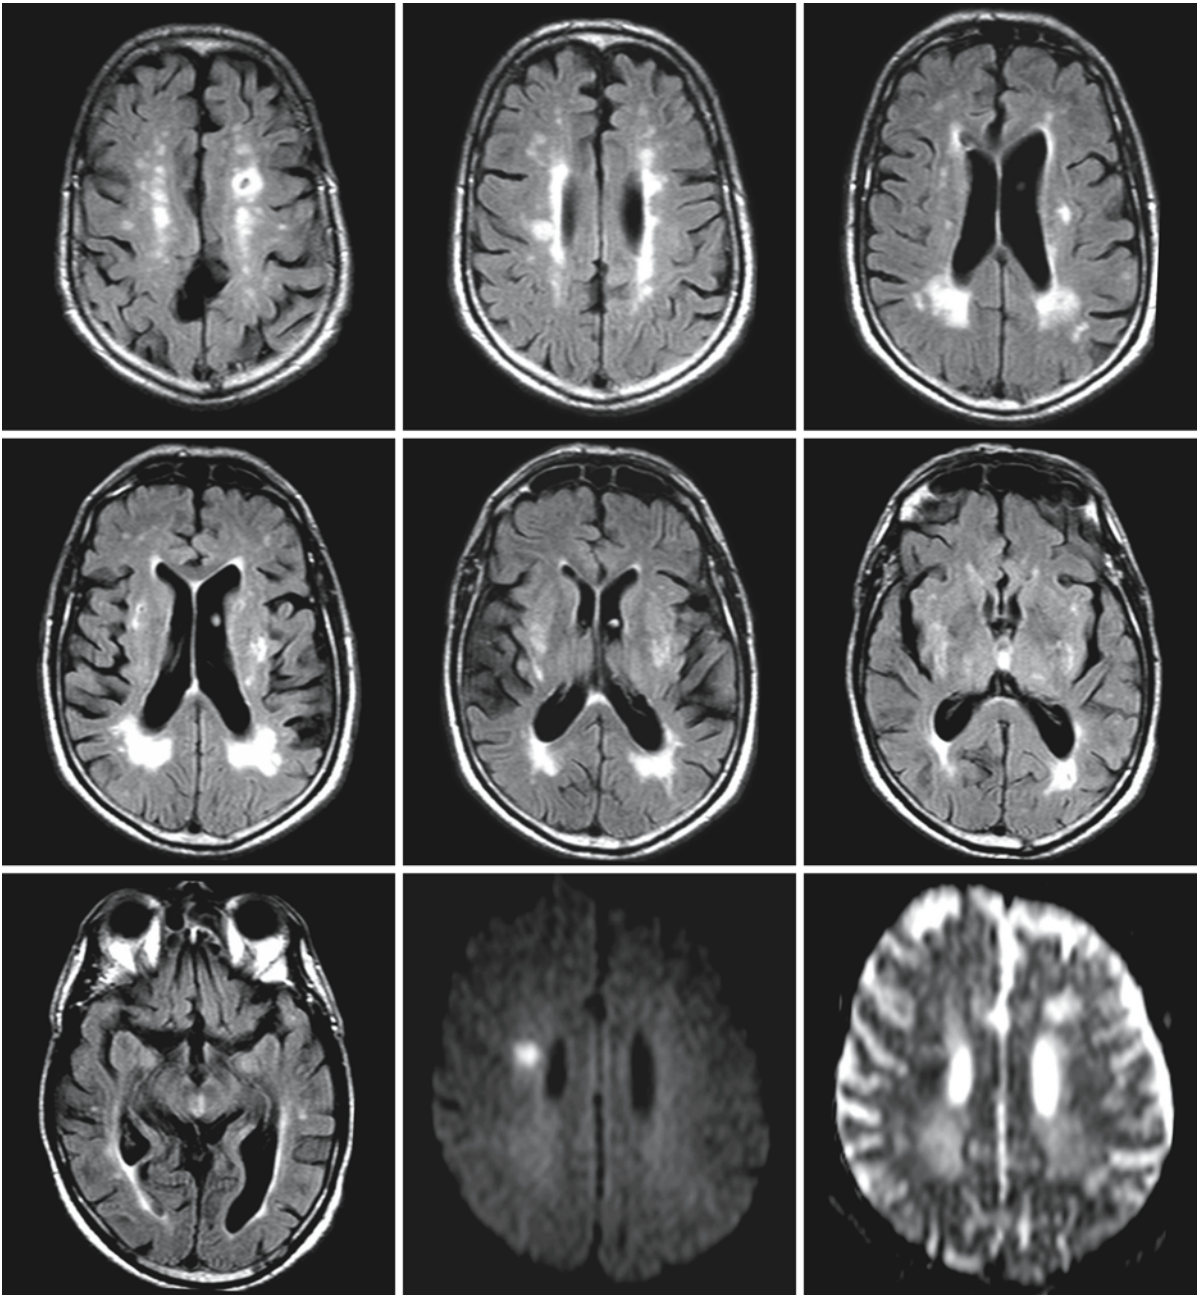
FLAIR images of a 71-year-old man presenting with mild apraxia of the left arm and no cognitive impairment. In the periventricular white matter hyperintensities a few lacunar
